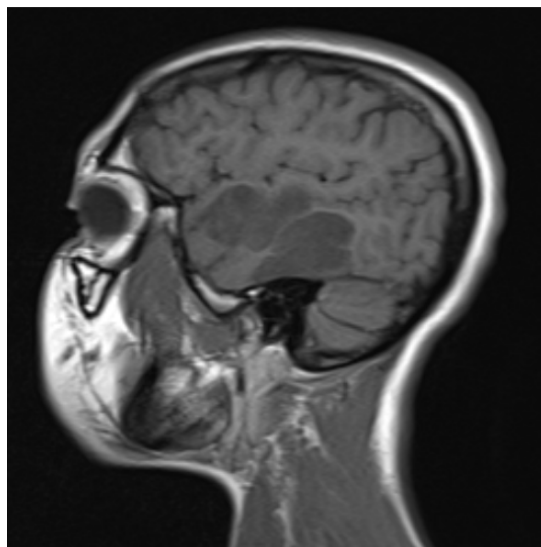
Brain MRI in T1-weighted sagittal section showing a left temporal corticosteroid lesion in hypo signal, seat of a fleshy area in hypo signal
